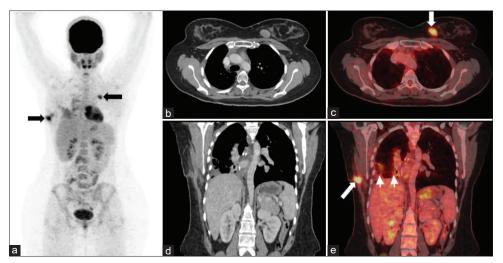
Maximum-intensity projection image showing fluorodeoxyglucose avid lesions in the right lateral chest wall left chest wall region anteriorly (a, arrows). Corresponding axial computed tomography (b) and fused (positron emission tomography–computed tomography) images (c) at the level of breast lesion showing a fluorodeoxyglucose avid well-defined soft-tissue density nodular lesion in the left breast upper inner quadrant (arrow). Coronal images of the computed tomography (d) and fused positron emission tomography–computed tomography (e) at the level of right lateral chest wall lesion showing increased fluorodeoxyglucose uptake along the surgical scar (arrow), postoperative and postradiotherapy changes in the right lower thoracic cavity (arrow heads)
